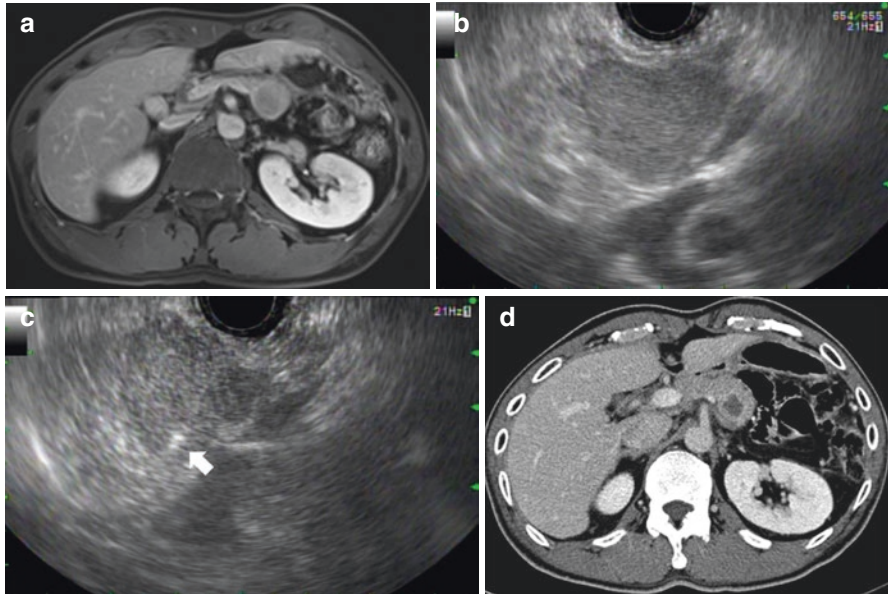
(a) MRI shows neuroendocrine tumor at the pancreas body. (b) EUS shows well-demarcated hypoechoic mass at the pancreas. (c) EUS-guided RFA began at the right distal portion of the mass on EUS image (*arrow*). The ablation was repeated at different sites. (d) Follow-up CT on 1 month after RFA shows necrosis of the tumor
